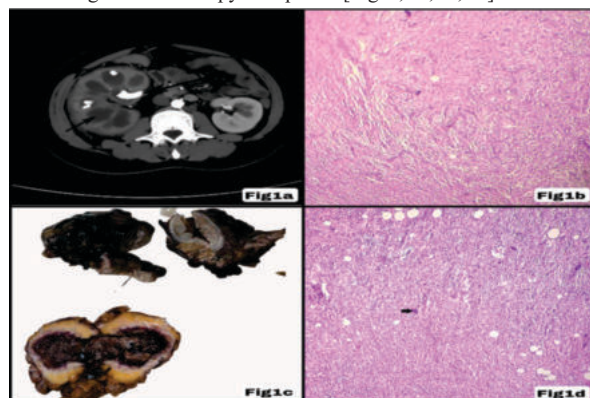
CT image of left kidney showing Bosniak III/IV cyst with nephrolithiasis (Case 1)
